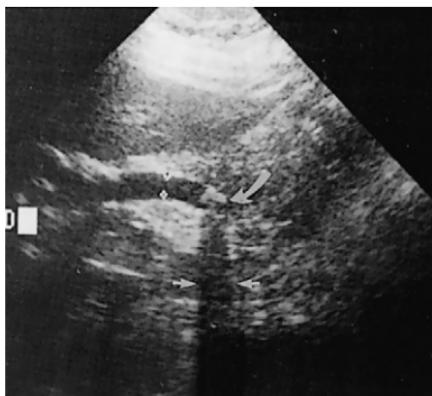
Ultrasound image of the distal common bile duct. A single echogenic stone (curved arrow) is present in the dilated distal common bile duct. Posterior acoustical shadowing (arrows) is also noted.
